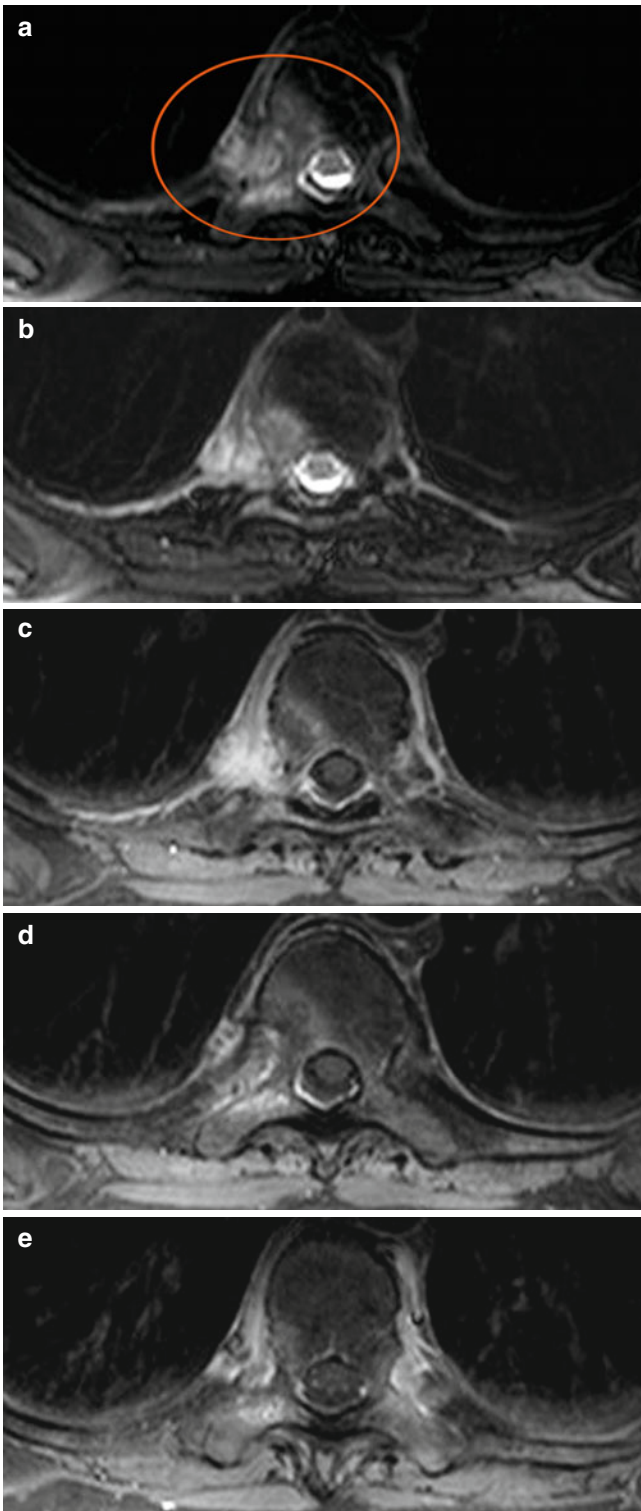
Axial TSE T2-weighted images with fat saturation (a–b) and SE T1-weighted images with fat saturation following the administration of contrast medium (c–e). These images demonstrate bone marrow edema in the costovertebral joint on the right side (a–b, *circle*); after contrast medium administration, note enhancement of right costovertebral joint T10–T11 (osteoarthritis) (d) with fogosis of adjacent soft tissue (c–e)
